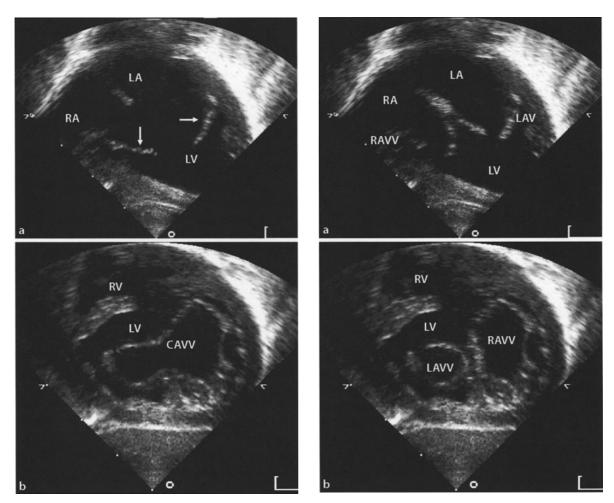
Single ventricle: echocardiography. a 4-chamber view showing a single ventricle of the left ventricular type with a common atrioventricular valve (white arrows) (*LA* left atrium, *LV* left ventricle, *RA* right atrium), b short-axis view in the same patient showing the single ventricle of the left ventricular type with the common atrioventricular valve (*CAVV* common atrioventricular valve, *LV* left ventricle, *RV* right ventricle) (photographs courtesy of Dr. Michael Rigby)
